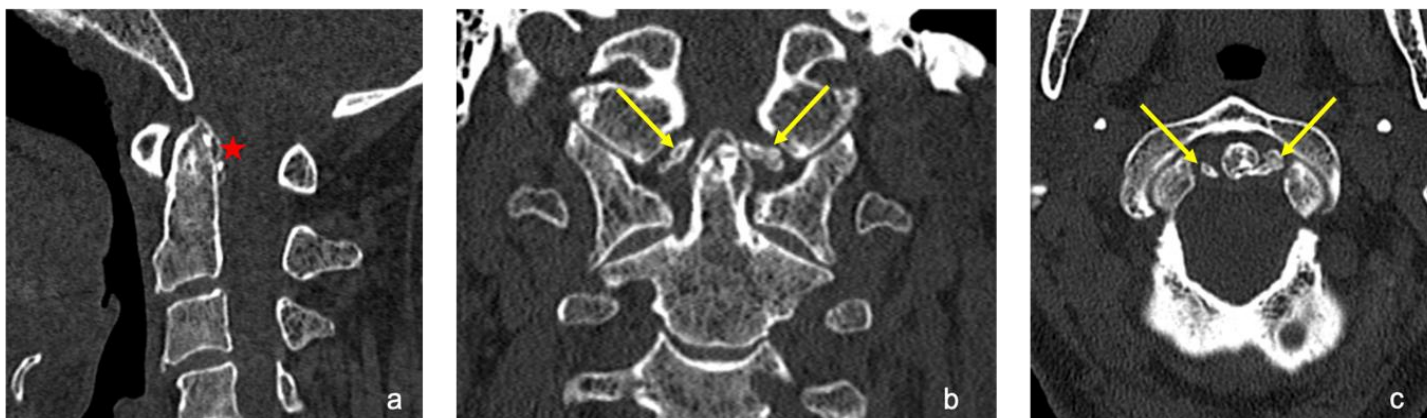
CT scan images in the bone window show: (a) calcification of the transverse ligament (red star) on the sagittal view, and calcification of the alar ligaments (yellow arrow) on (b) the coronal and (c) transverse views.
